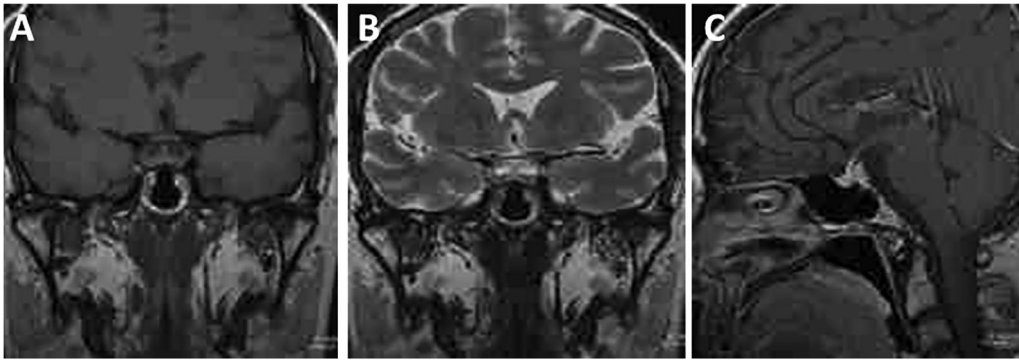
Magnetic resonance imaging of the pituitary in patient 1 upon hospital admission. (A) Coronal T1-weighted image. (B) Coronal T2-weighted image. (C) sagittal image.
